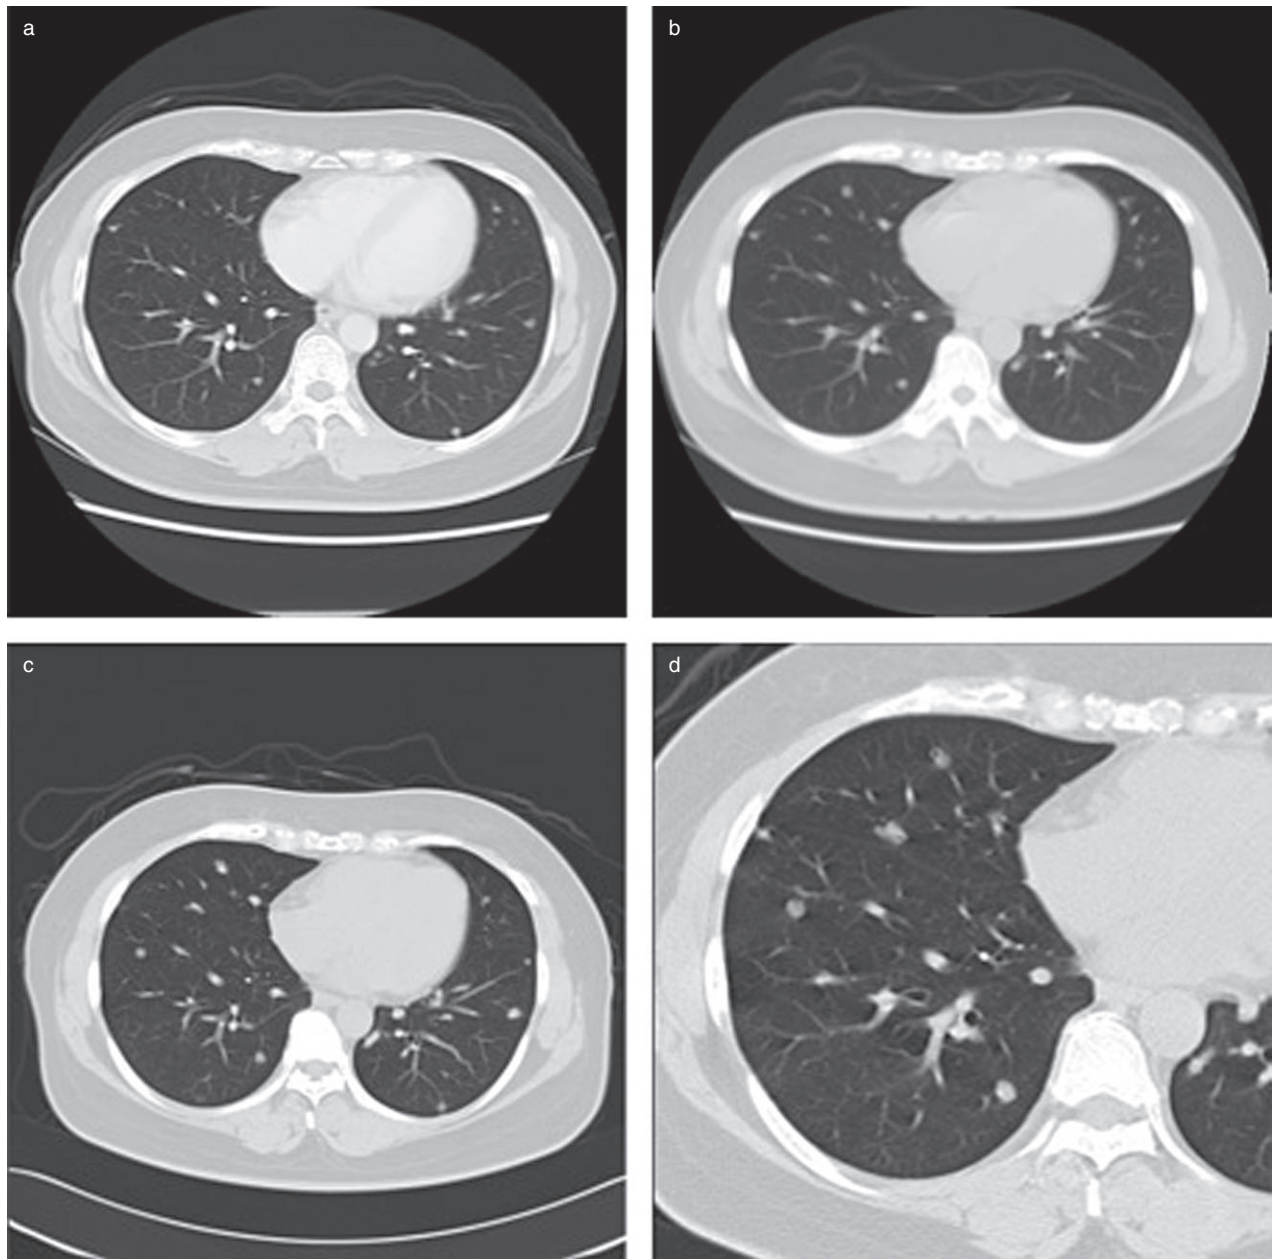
Chest computed tomography showing the four-year natural clinical course. (a) Before biopsy, (b) one year after biopsy, and (c) four years after biopsy. (d) Magnified image of pulmonary lesions four years after biopsy.
